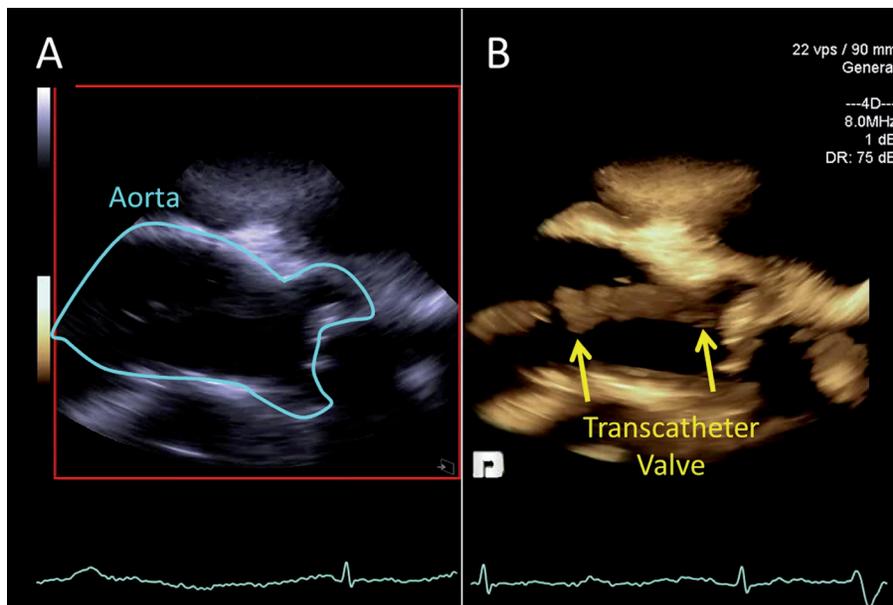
Intra-cardiac echocardiography (ICE) during transcatheter aortic valve replacement (TAVR). Panel A is the two-dimensional ICE image with panel B showing the simultaneous three-dimensional volume during positioning of the transcatheter aortic valve (yellow arrows).
